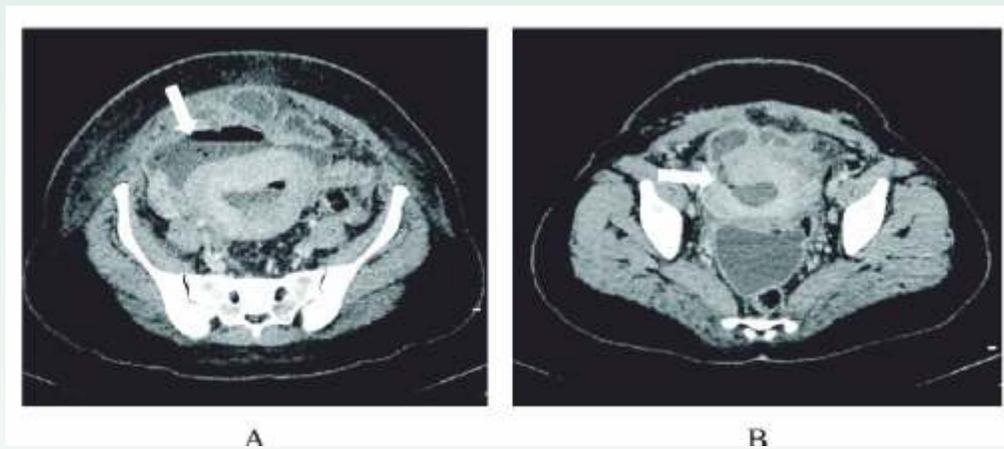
Computed tomography demonstrating a) fluid collection anterior to the uterus that communicates with the endometrial cavity and b) defect in the anterior wall of the uterus
